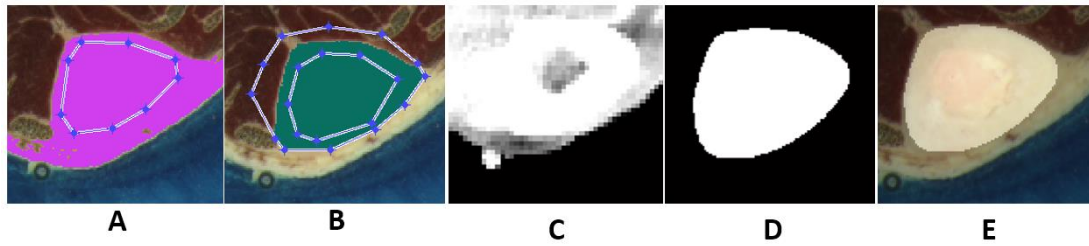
Integration of CT and cryosection images.
